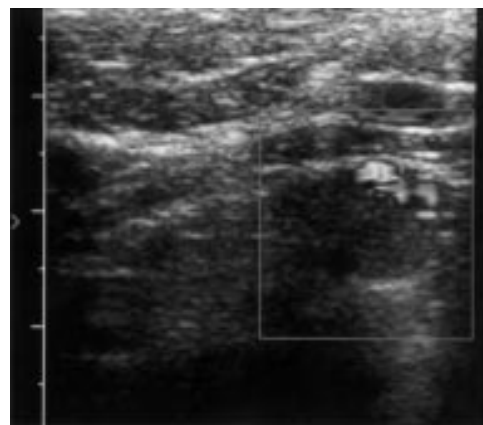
Parathyroid ultrasound examination.
